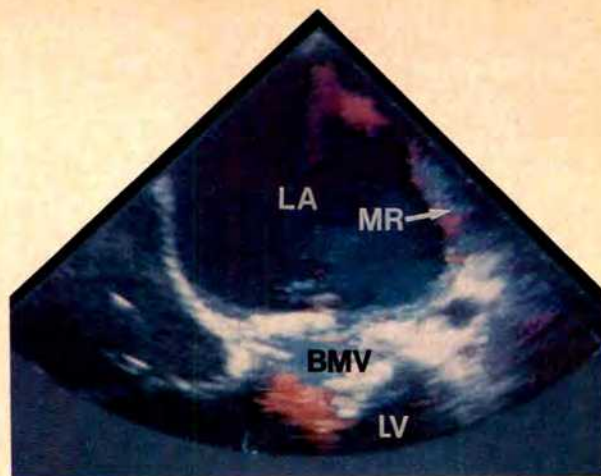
Transesophageal color flow Doppler of patient in Figure 2 with stenotic bioprosthetic mitral valve (BMV). Note narrow mitral regurgitant jet (MR) occupying <20% of left atrial chamber. LA = left atrium; LV = left ventricle.
